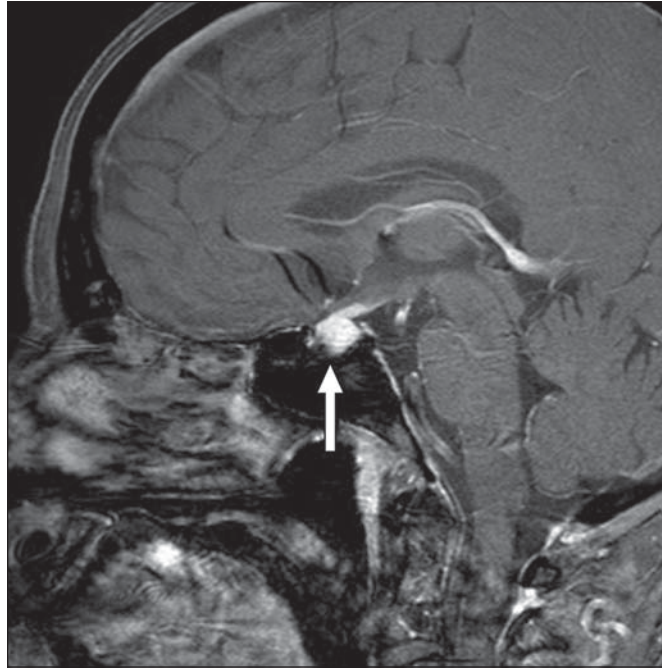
71-year-old man receiving ipilimumab for treatment of metastatic melanoma who presented with new-onset headache. Sagittal T1-weighted contrast-enhanced brain MR image shows mild enlargement of pituitary gland (*arrow*) with convex superior margin, suprasellar extension, and diffuse enhancement of pituitary gland. Endocrinologic assessment confirmed hypopituitarism consistent with ipilimumab-induced hypophysitis.
